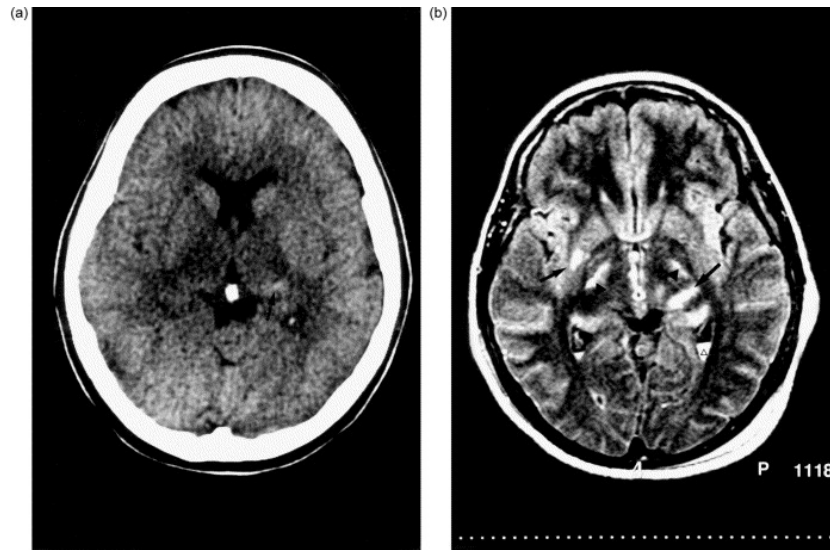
Difference between a CT (a) and a MRI (b) in a 19-year-old male with severe closed head injury [70].
